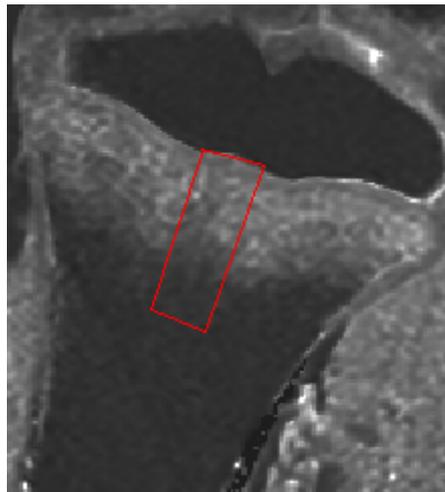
Quantification of metaphyseal water content on short echo time T1 MR images using SisWin.
